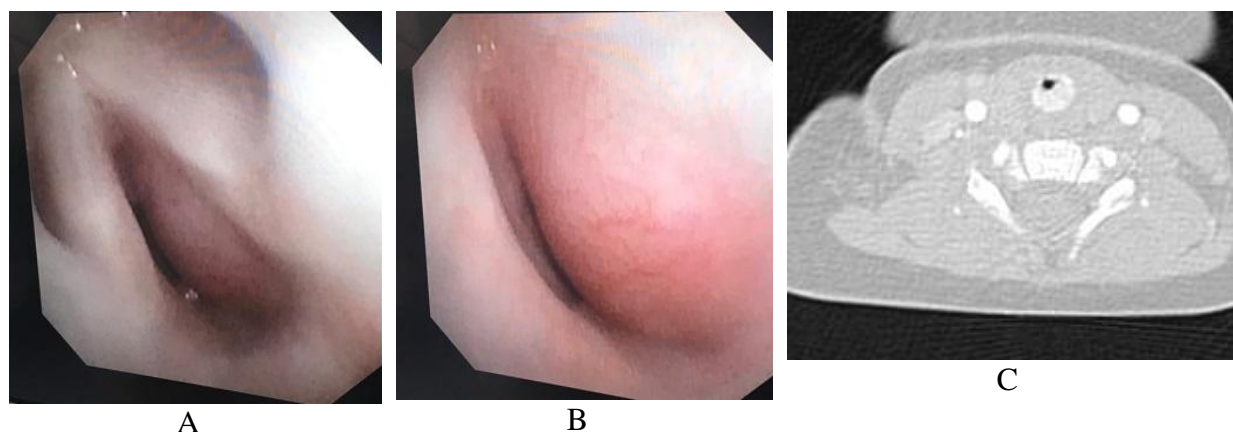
Videolaryngoscopy (A, B) and CT with contrast enhancement (C) showing subglottic hemangioma in an infant
